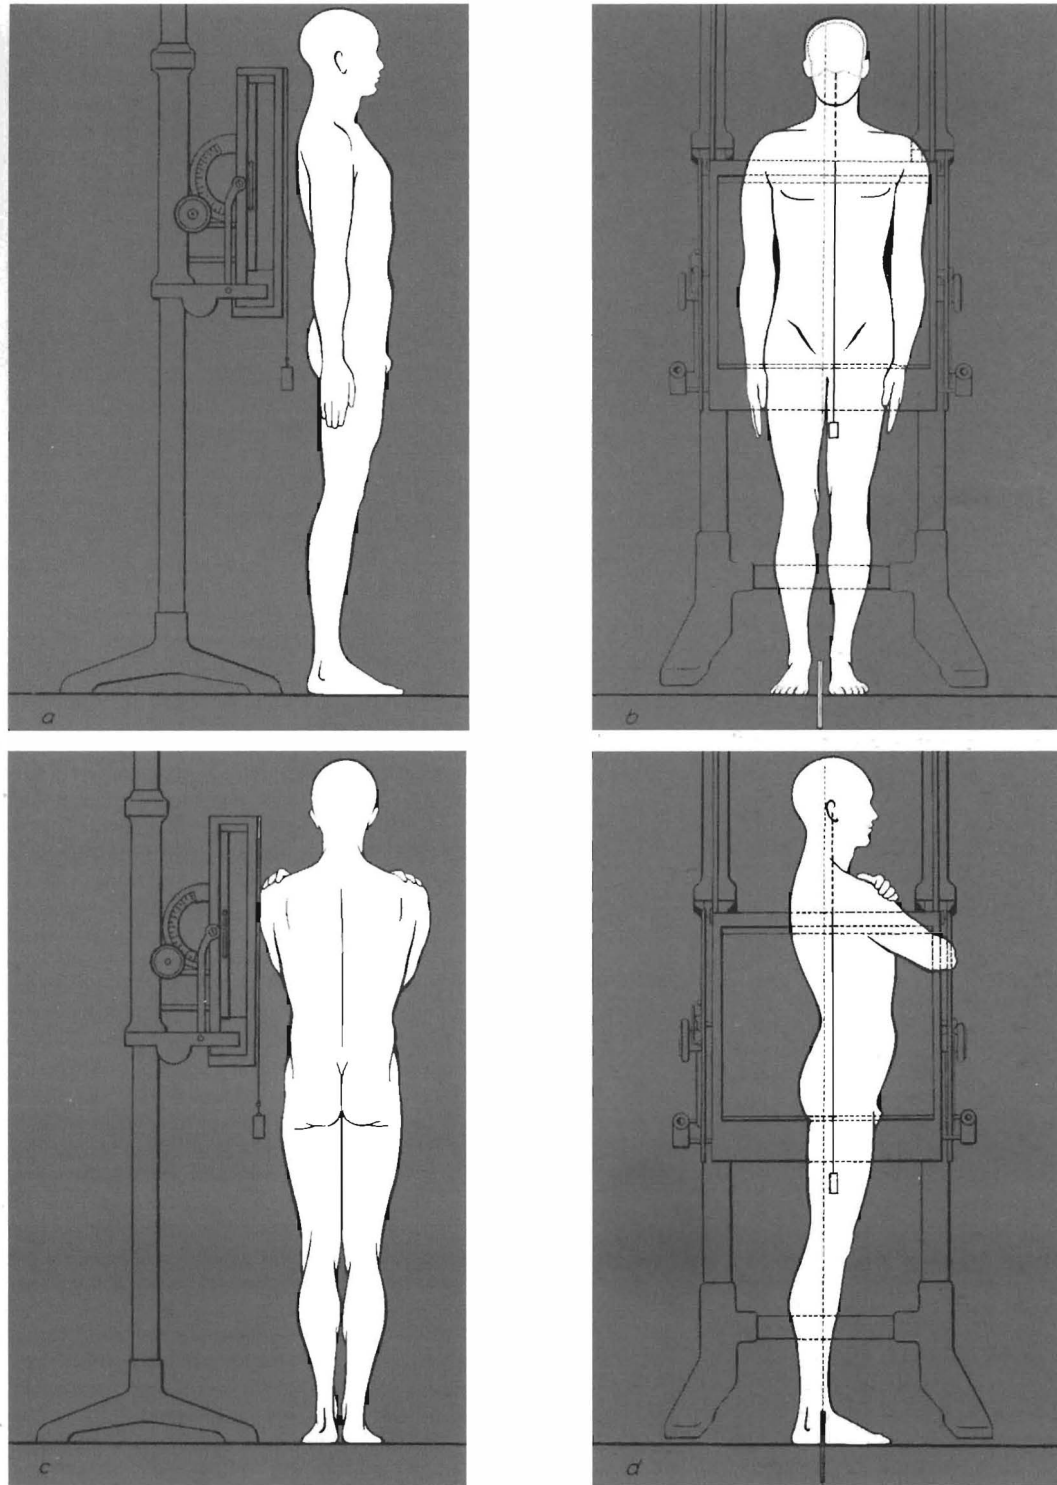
X-ray technique of the lumbar spine with the patient standing. (a) Positioning of the moveable plumb-line; (b) the device prepared for X-ray, AP view; (c) positioning of plumb-line; (d) the device prepared for X-ray, lateral view (After Gutmann, 1970)
